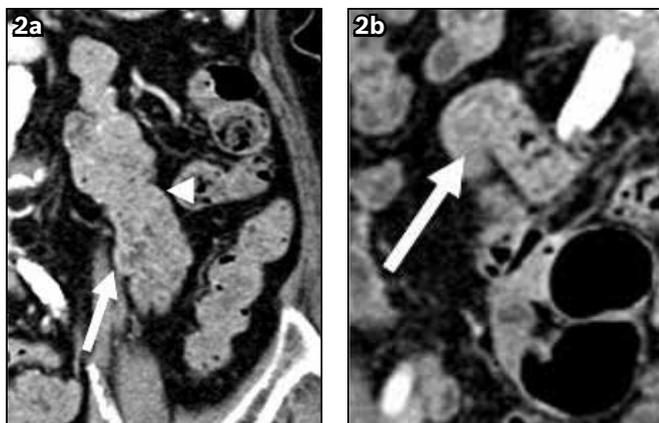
Abdominal CT images of an 81-year-old woman who received water as an oral contrast agent. (a) Grade 2 bowel distension (white arrow) and poor discrimination of the bowel loops (white arrowhead) are seen for the jejunum. (b) Poor mural and mucosal fold visualisations (white arrow) are seen for the ileum.
